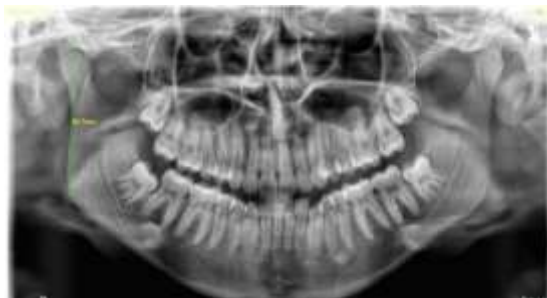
The approach used to measure ramal length on a representative panoramic radiograph investigated.
